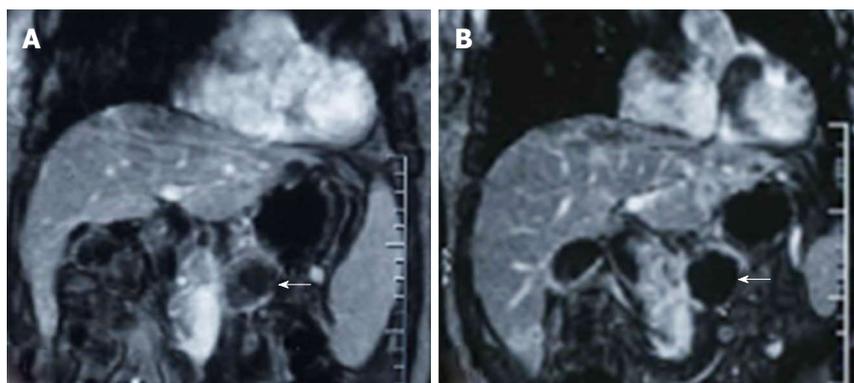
Contrast-enhanced T-weighted MR images obtained in a patient treated with high intensity focused ultrasound for advanced pancreatic cancer. The tumor was 4.5 cm in diameter and located in the body of the pancreas. A: Image obtained before high intensity focused ultrasound (HIFU) shows blood supply in the pancreatic lesion (arrows); B: Image obtained 2 wk after HIFU shows no evidence of contrast enhancement in the treated lesion (arrows), which is indicative of complete coagulation necrosis in the treated pancreatic cancer.
